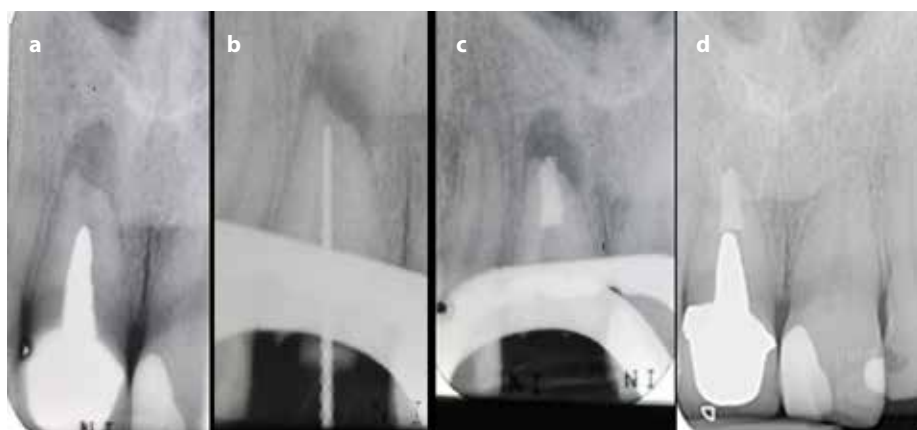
(a) UR1 with long post-retained crown, apical resorption and chronic suppurative periradicular periodontitis. (b) Dismantled post-retained crown and working length radiograph in orthograde treatment approach. (c) Immediate post-operative radiograph following placement of tooth-coloured ProRoot MTA apical plug. (d) 15 month post-operative radiograph showing continued healing.
